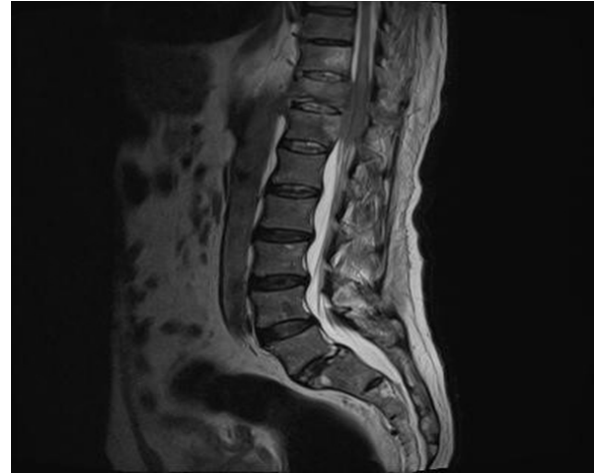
A sagittal T2W MRI showing posterior disc bulge at L5/S1 level causing impingement over both exiting nerves.
